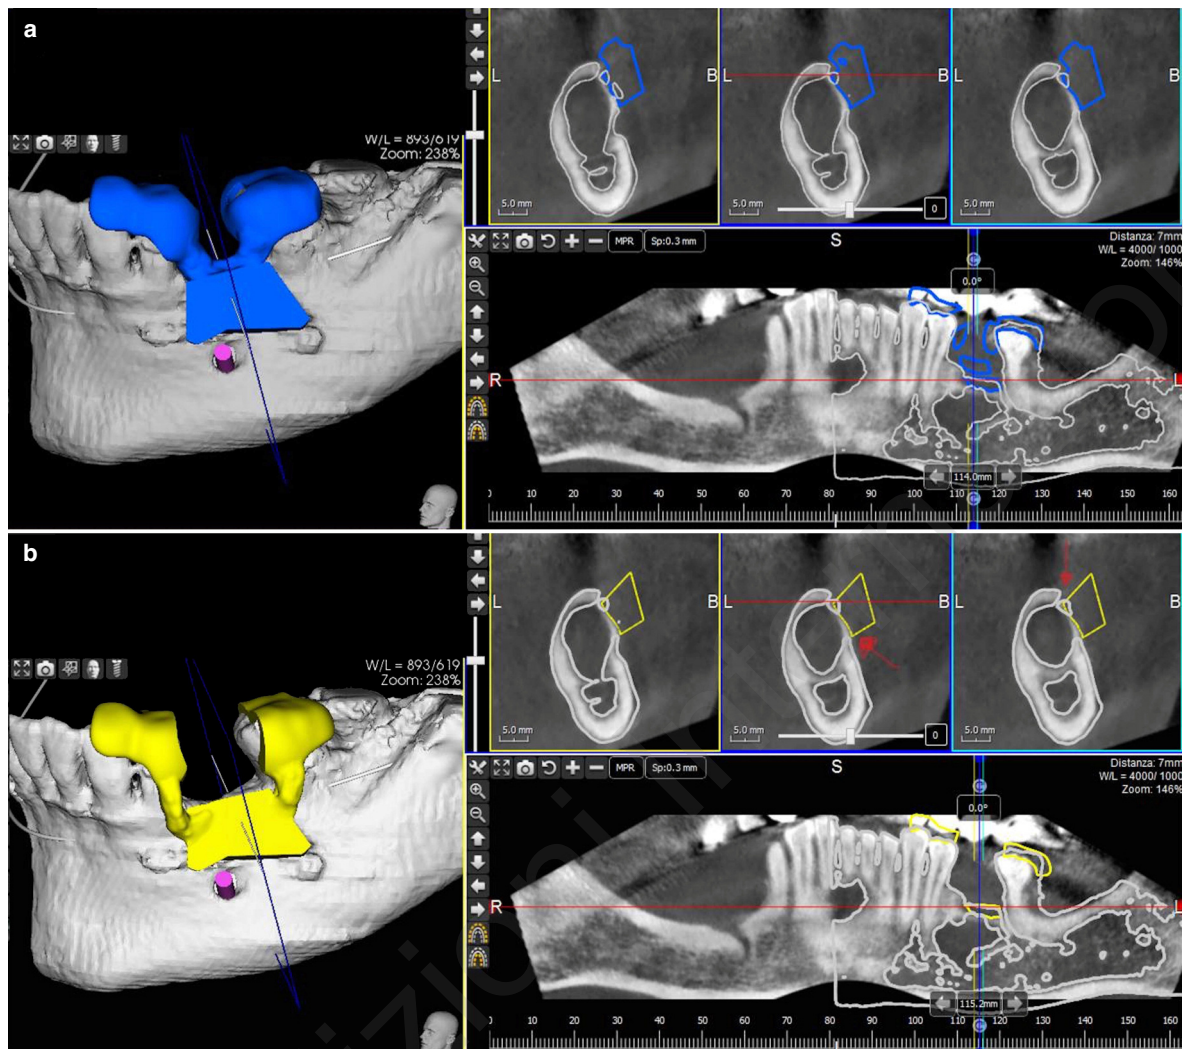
The first (a) and second (b) templates superimposed on the postoperative CBCT. The osteotomies coincide well with the templates' surfaces.
